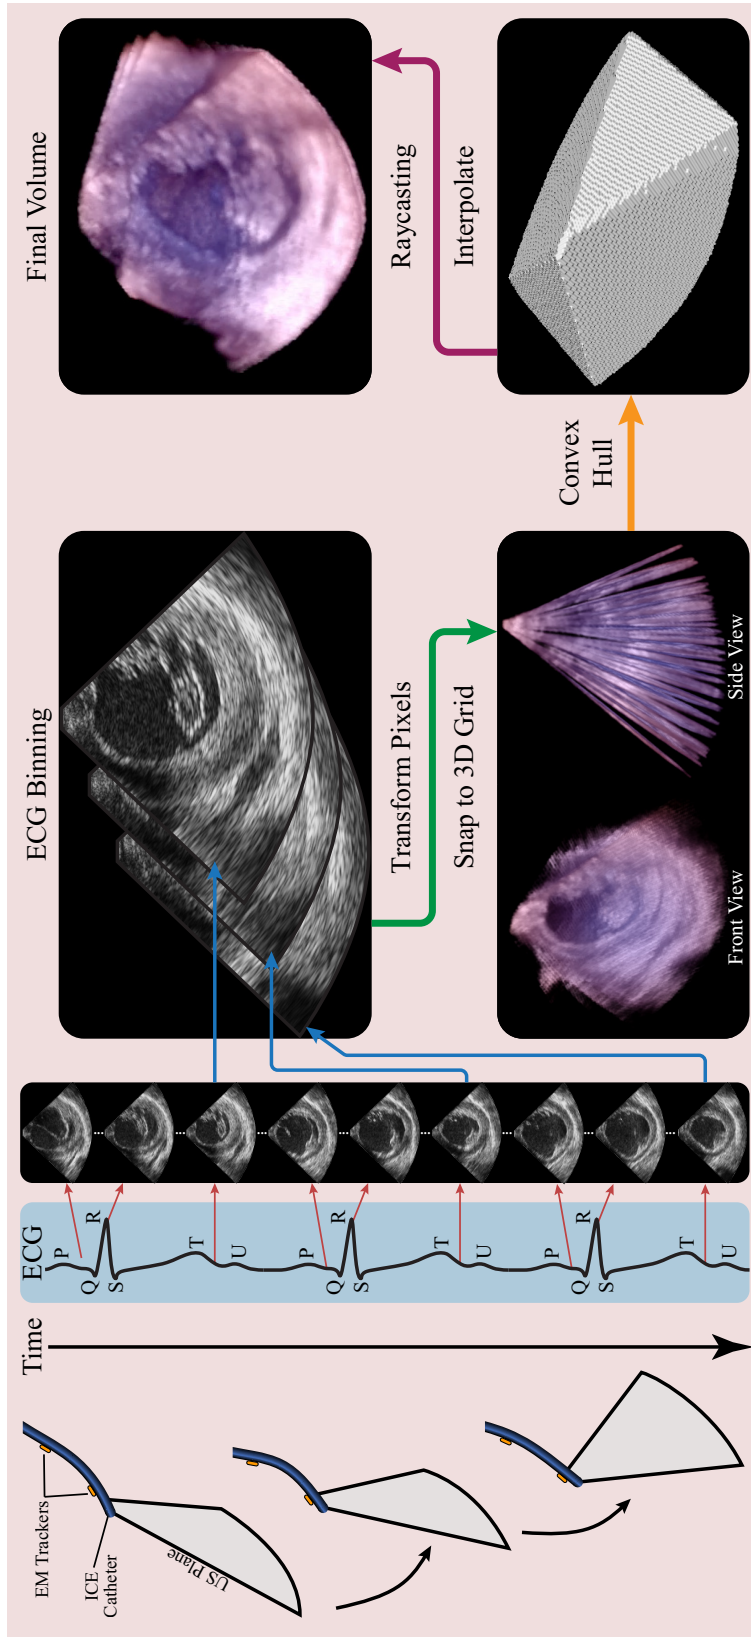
3D reconstruction pipeline. Ultrasound images are binned according to their cardiac phase. Pixels are transformed in space based on the EM sensor readings and placed in a volumetric grid. The convex hull of these voxels defines the interpolation boundary, which is required to inpaint the gaps between the slices.
